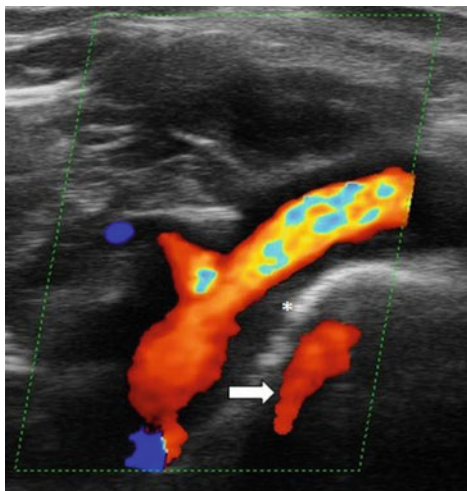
Proximal left subclavian artery in large-vessel giant cell arteritis (see chapter “[Ultrasound in Vasculitis](#)”). The clavicle (*) serves as strong reflector. The color signal of the subclavian artery is mirrored on the other side of the clavicle
